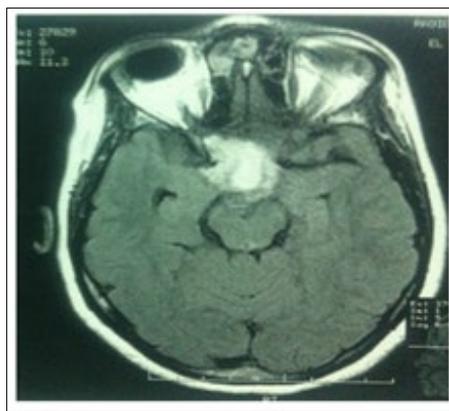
MRI: Chiasmatic glioma.
